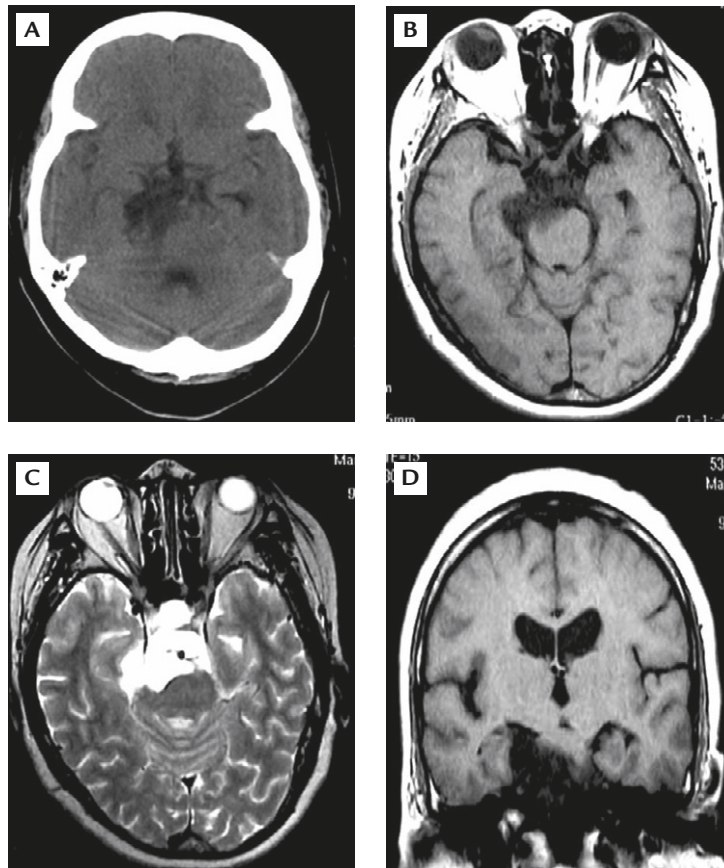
Unenhanced computed tomography and magnetic resonance imaging obtained 6 years before the surgery. (A) Low-density area. (B and D) Slightly long T1 intensity lesion, and (C) a slightly long T2 intensity lesion in the right cerebellopontine angle and prepontine cistern can be seen in the right cerebellopontine angle and prepontine cistern. The brain stem is compressed.
